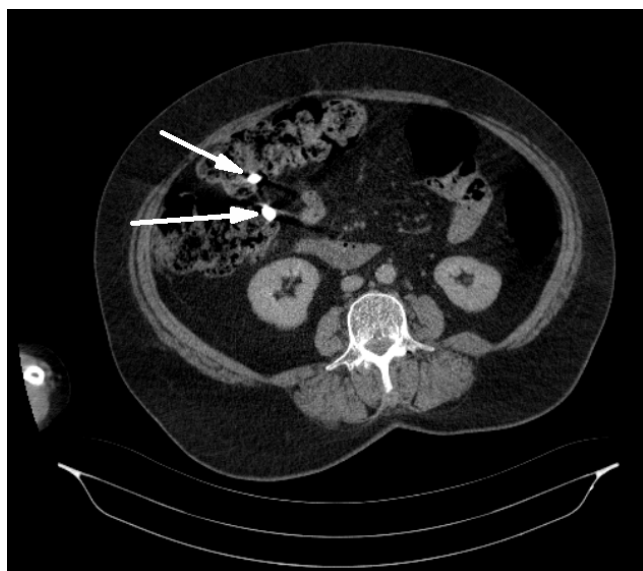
Nodular foreign bodies with dense calcific-metallic character on abdominal computed tomography
